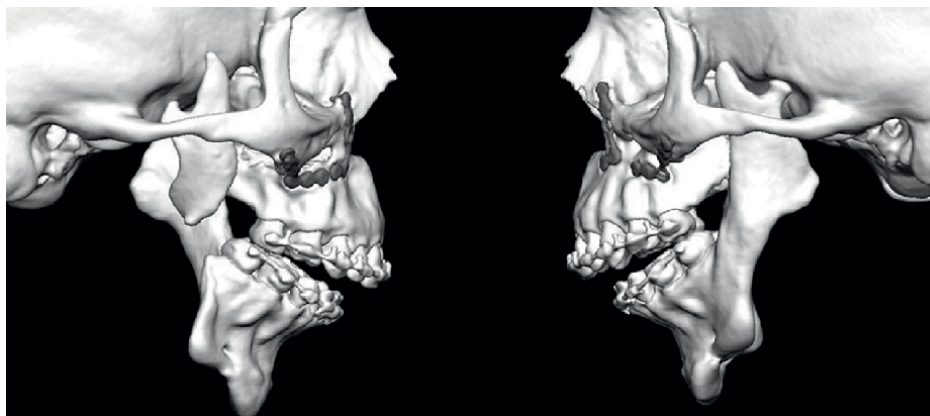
Preoperative CT images showing a right sided mandibular continuity defect and left sided condylar dislocation into the infratemporal fossa. Maxillary hardware from previous corrective orthognathic surgery is also seen. This aberrant anatomy shown in this image highlights the need for extended patient-matched prostheses for temporomandibular joint reconstruction.
